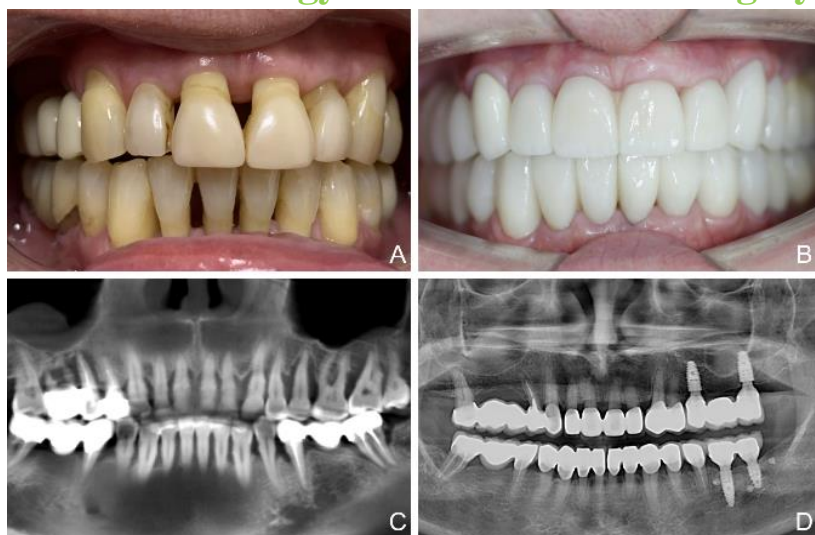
A. The situation before treatment. B. The situation after full mouth rehabilitation. C. CBCT screenshot before treatment. D. Panoramic X-ray after final prosthetic rehabilitation.
